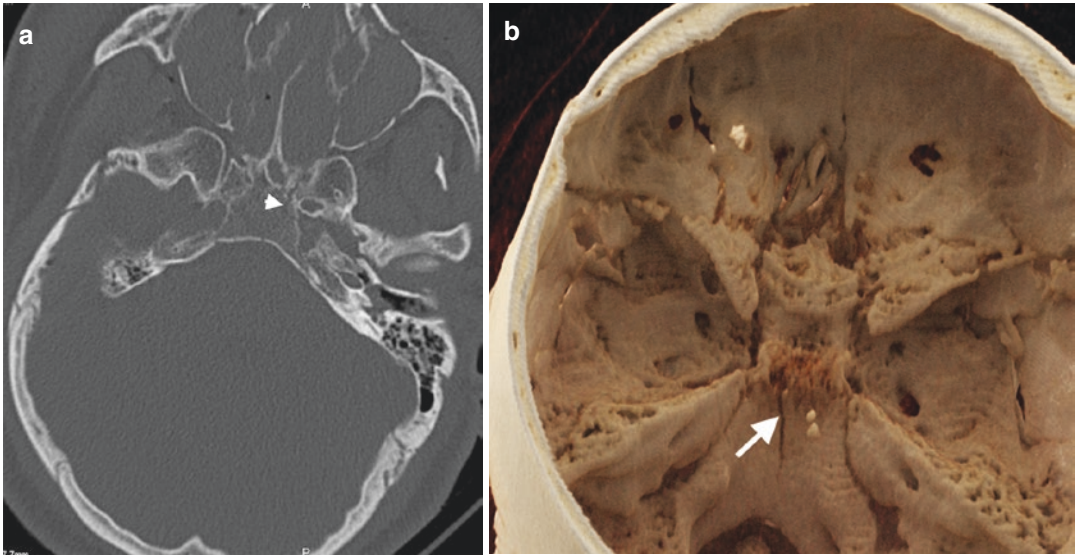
Linear fracture in clivus. (a) Axial CT image on bone window demonstrates a subtle linear fracture (arrow-head) in clivus. (b) CR image demonstrates longitudinally oriented linear fracture (arrow) at the cranial aspect of the clivus
